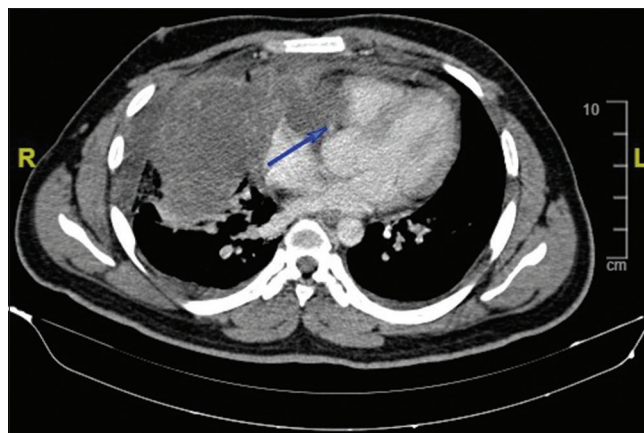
Computed tomography thorax, showing anterior mediastinal mass
